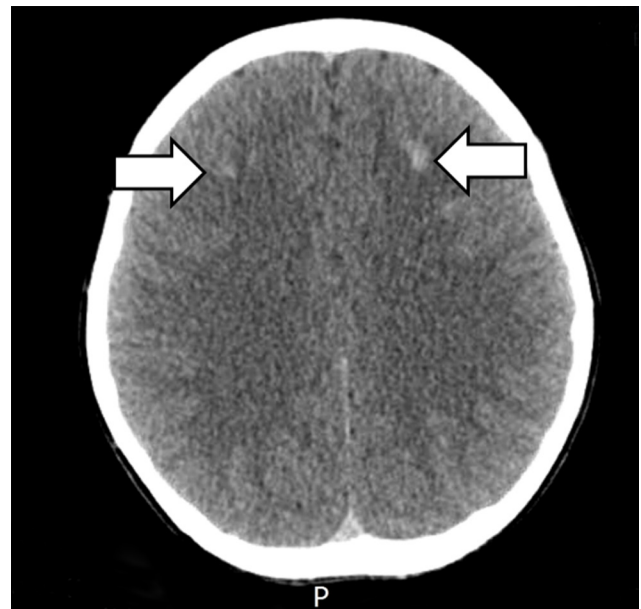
The brain CT scan. Multiple high density nodular lesions in the bilateral basal ganglia and subcortical white matter of the frontal lobe.
